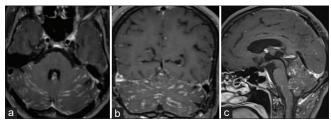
Contrast enhanced T1 weighted MRI showing cerebellar folial enhancement in axial, coronal and sagittal views in A, B, C respectively
